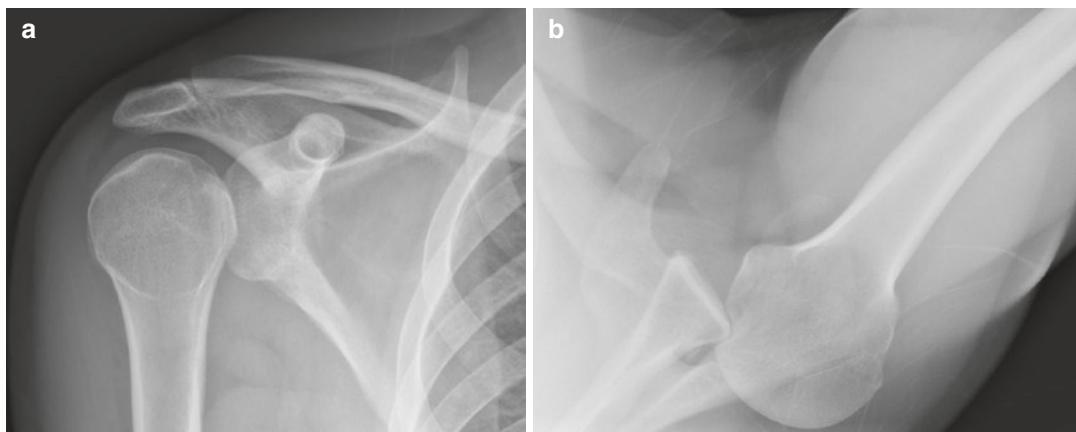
Forty-four-year-old man with posterior shoulder dislocation. (a) AP internal (not shown) and external rotation radiographs show persistent internal rotation appearance of the humeral head on both views. Trans-scapular Y view (not shown) demonstrates questionable
